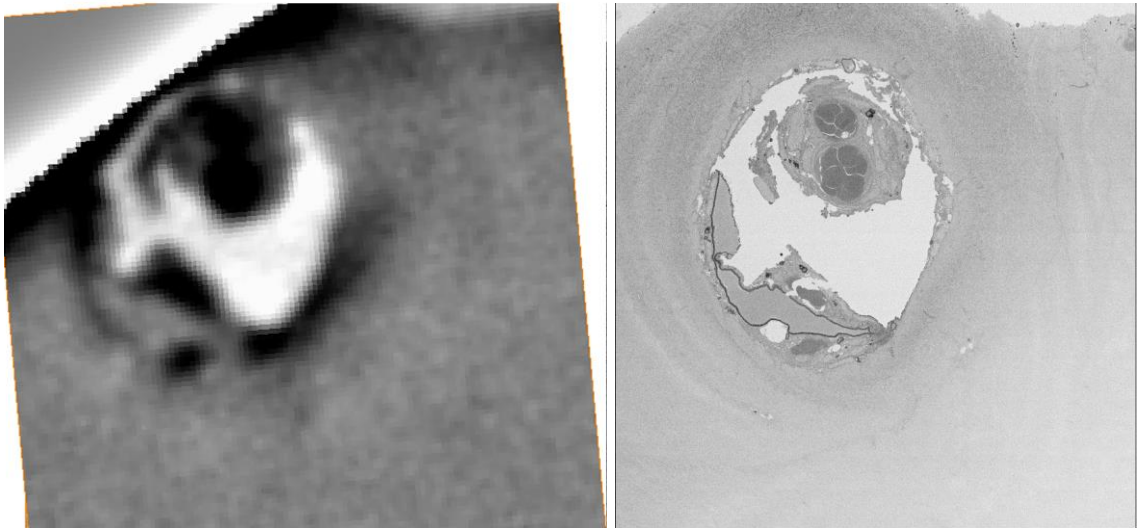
Correlative X-ray and SBFSEM images of an osteon in human bone tissue.
